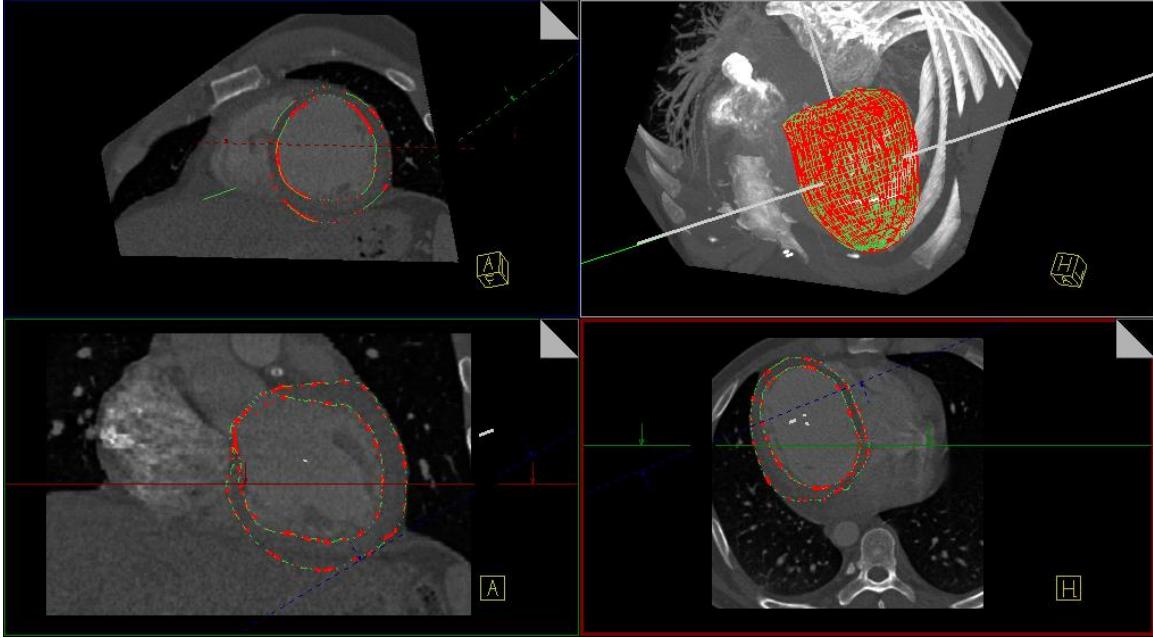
Geodesic models after TPS algorithm for patient 1. Only CTA volume is shown for clarity of presentation.
